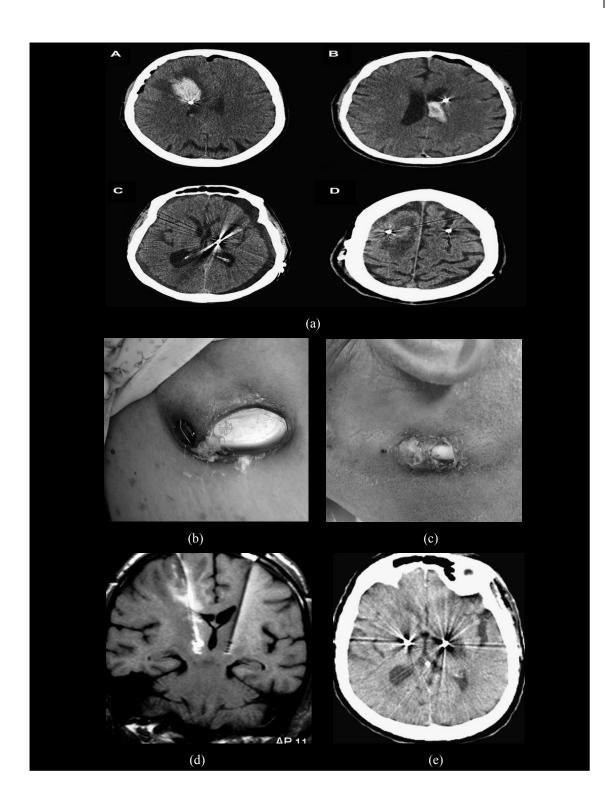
(a) CT scan images depicting examples of intracerebral hemorrhage following DBS lead implantation : intracerebral hemorrhage (A) intraventricular hemorrhage (B) subdural hemorrhage (C) and venous infarction (D) (reproduced with permission from Morishita et al. 2010) (b) IPG implantation site infection (reproduced with permission from Boviatsis et al. 2010) (c) Erosion of retroauricular skin due to implanted DBS system (reproduced with permission from Linhares et al. 2013) (d) Postoperative T1-weighted MRI showing hyperintense signal due to infection of the right electrode (reproduced with permission from Vergani et al. 2010) (e) Axial CT scan without contrast on post-operative day 4 at (a) the tip of the electrode showing a large hypodense area (edema) around the left deep brain stimulation electrode (reproduced with permission from Deogaonkar et al. 2011).
